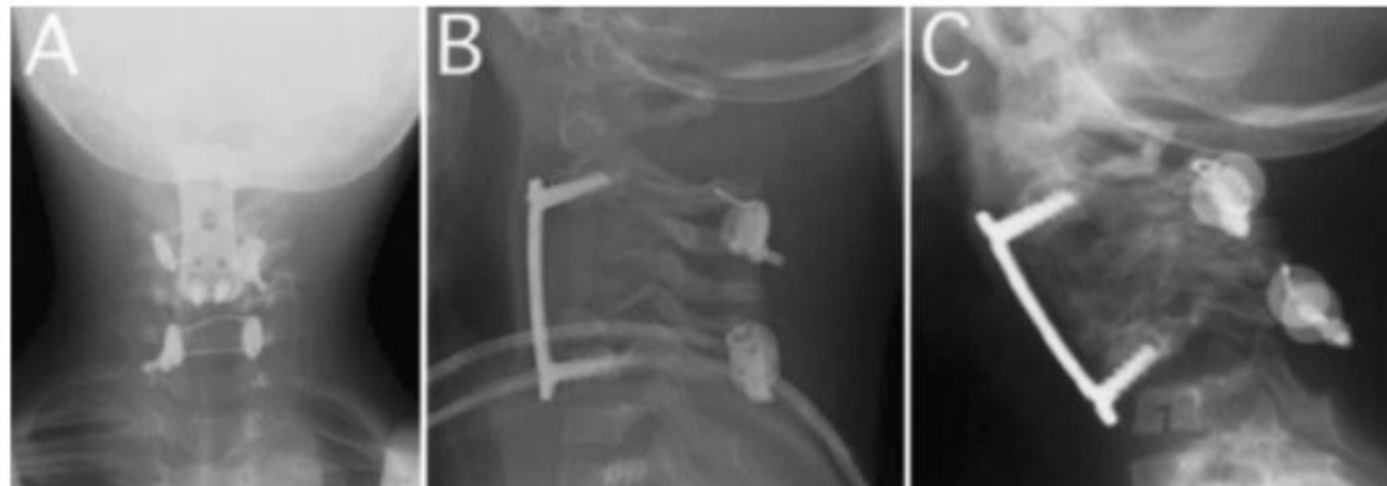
Case 2. Anteroposterior (A), lateral (B), and flexion (C) plain x-ray films obtained postoperatively. Note the instability that developed at the C6-7 level with flexion; the lateral masses almost become perched. This required an extension of the posterior construct.
